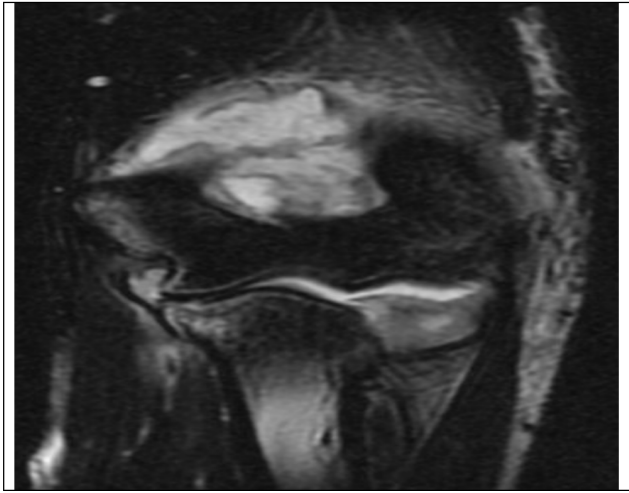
Coronal T2-weighted magnetic resonance image demonstrating a large joint effusion with heterogeneous internal signal and synovial inflammatory change, compatible with septic arthritis.
